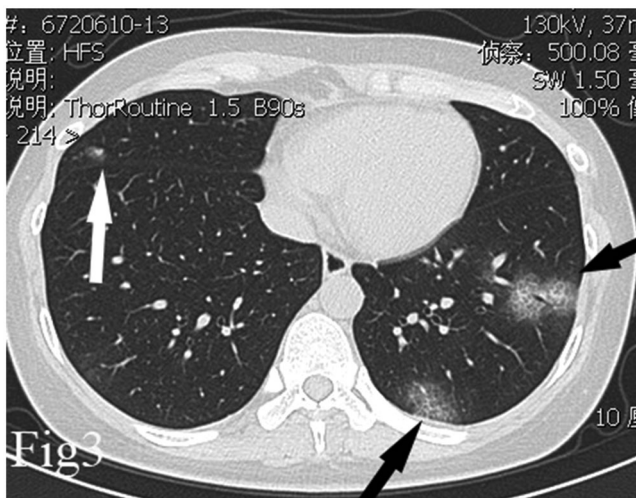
A 32 year old female patient diagnosed with mild COVID-19, with a chief complaint of “headache for two days”. The CT showed focal GGOs with a central thickening of airway wall (white arrow) on the right middle lobe, which we named as dandelion sign, and focal GGO with thickening interlobular septa (black arrows) on the left lower lobe, which we named as focal crazy paving sign.
